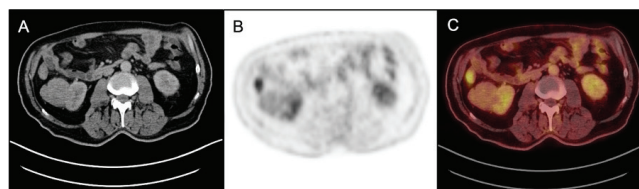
Axial CT (A), PET (B), and fusion PET/CT (C) images of a 67-year-old living patient with stage 1 cancer were received 7.4 years ago. He had chromophobe type RCC in the right kidney with a SUV_{max} value of 3.9
